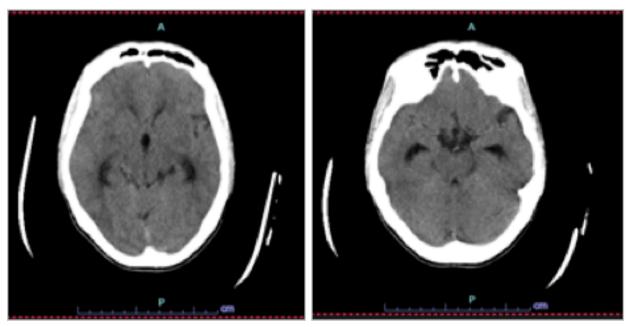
A plain cranial CT suggestive of hydrocephalus: increased size of the lateral horn of the lateral ventricles, as well as enlargement of the third ventricle.
